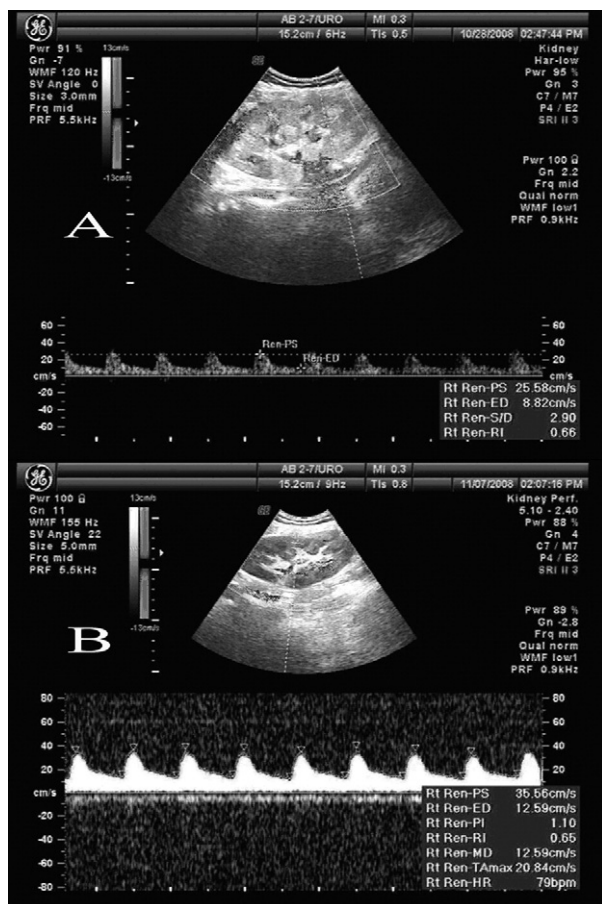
(A) Sonogram of acute urate nephropathy reveals graft enlargement and increased echogenicity of renal parenchyma. (B) After treatment, graft presents normal on ultrasonography.
